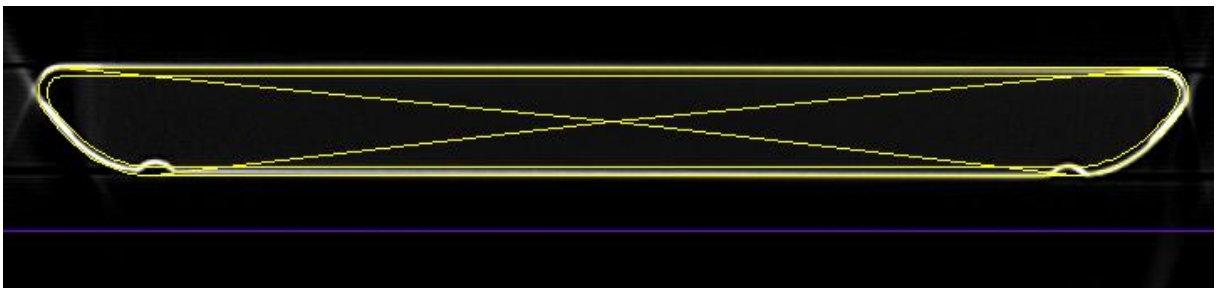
The couch model structures on the CT scan of the Varian IGRT couch at a level between the H3 and H4 notches
